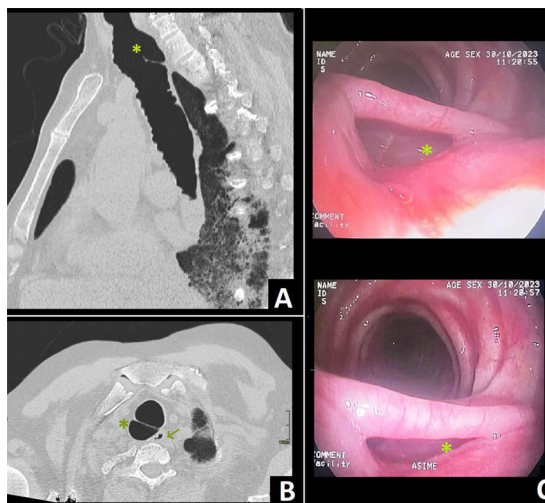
(A) Thoracic CT with contrast, orthogonal plane, pulmonary window shows anorthogonal section of the tracheal diverticulum (*). (B) Thoracic CT with contrast, axial plane, pulmonary window shows an axial section of the tracheal diverticulum (*) as well as esophageal (arrow). (C) Bronchoscopy shows the presence of diverticulum (*).
